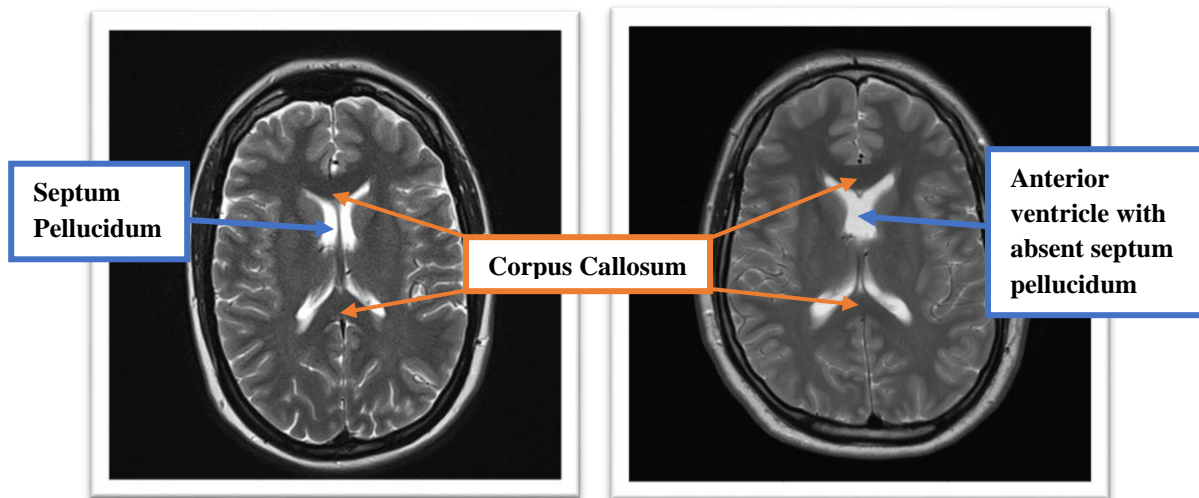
Left image: Normal MRI brain, axial view, demonstrating a normal septum pellucidum (blue arrow) and corpus callosum (orange arrows). Right image: MRI brain image, axial view, of our patient lacking the septum pellucidum (blue arrow). While absent or deformed corpus callosum are common in this condition, it was normal for our patient (orange arrows).
